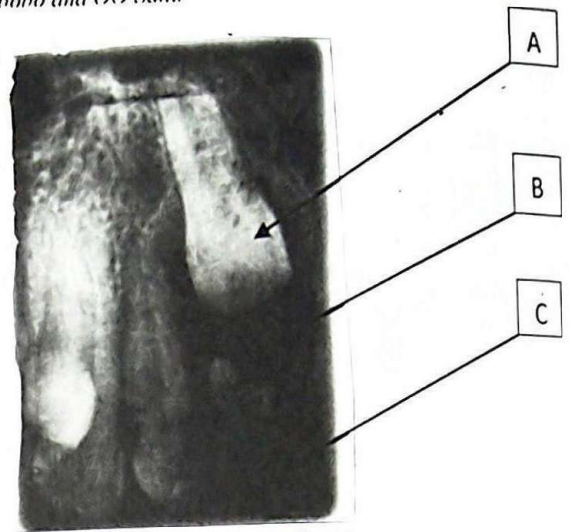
Periapical radiograph showing;
